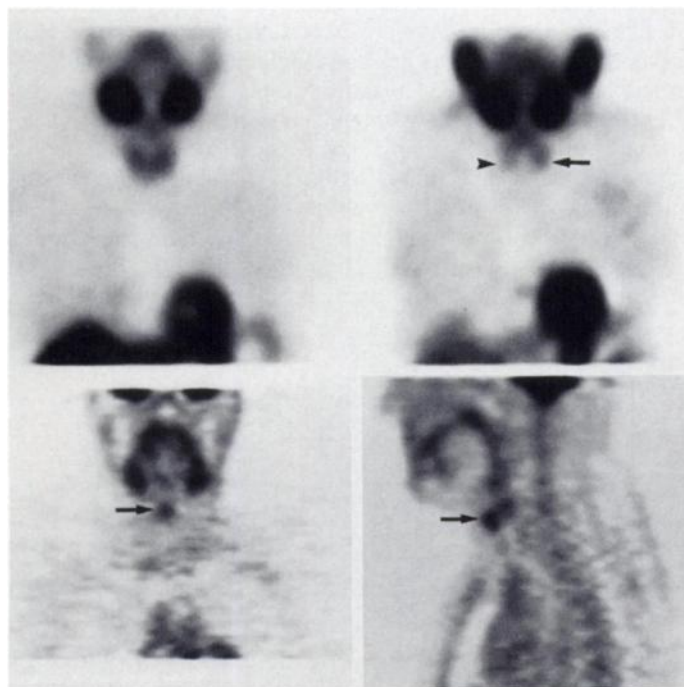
Discordant image results. A 450-mg parathyroid adenoma was found at surgery in the right upper neck. Sestamibi-SPECT shows clearance of activity from the right neck (arrowhead) but preferential retention of activity (arrow) in the left lower neck on (A) early and (B) delayed coronal tomograms. A normal left lower parathyroid gland was biopsied at surgery. FDG-PET shows increased uptake of activity in right upper neck (arrows) on (C) coronal and (D) sagittal tomograms.
